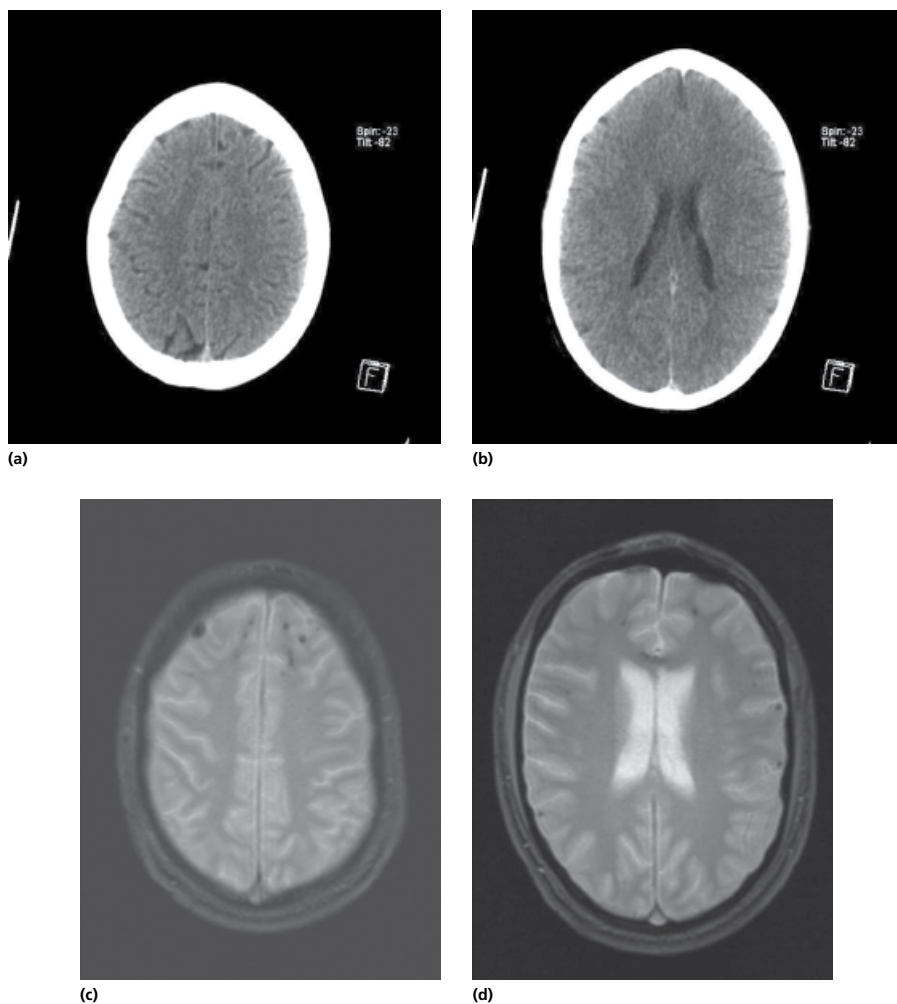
Patient with mild TBI, GCS 14 on admission, after a bicycle accident. CT on admission reveals no abnormalities (a and b). MRI performed 3 months after injury due to persisting cognitive complaints reveals microhemorrhages corresponding with diffuse axonal injury in the frontal regions bilaterally (c) and in the corpus callosum and in the cortex (d).
